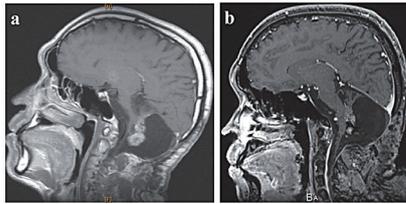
Contrast-enhanced sagittal T1-weighted MRI of the patient.
